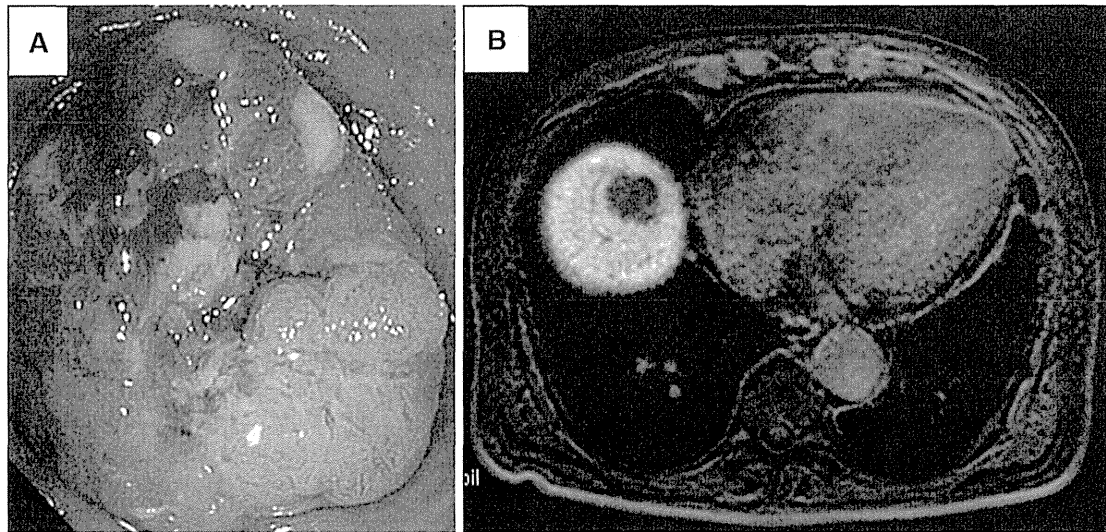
The colonoscopy and MRI for Case 2. a Colonoscopy revealed a sigmoid colon tumor that completely obstructed the colon. b MRI showed a metastatic tumor in S8 of the liver
